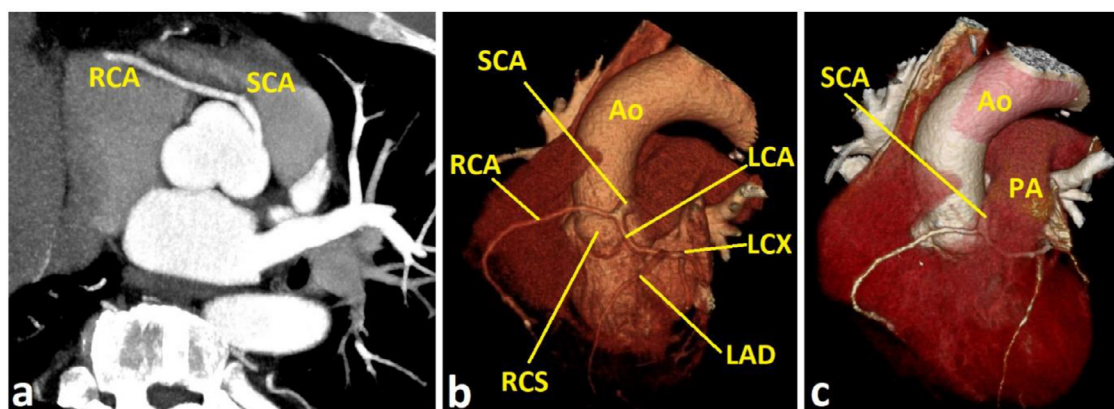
(A) Axial computed tomography angiographic image (in maximum intensity projection, MIP) at the level of sinuses of Valsalva demonstrates a single coronary artery (SCA) arising from the anterior aspect of the left coronary sinus; the right coronary artery (RCA) is arising from the SCA and not from the right coronary sinus; (B and C) show 3-dimensional reconstructed images confirming the same findings along with visualization of the inter-arterial course (ie, between the Ao, aorta and PA, pulmonary artery) of SCA during its antero-inferior descent before bifurcating into the RCA and the left coronary artery (LCA). These features are consistent with SCA-LIIB type according to Lipton-Yamanaka classification system. Ao, aorta; LAD, left anterior descending artery; LCA, left coronary artery; LCX, (left) circumflex artery; PA, pulmonary artery; RCA, right coronary artery; RCS, right coronary sinus; SCA, single coronary artery.
